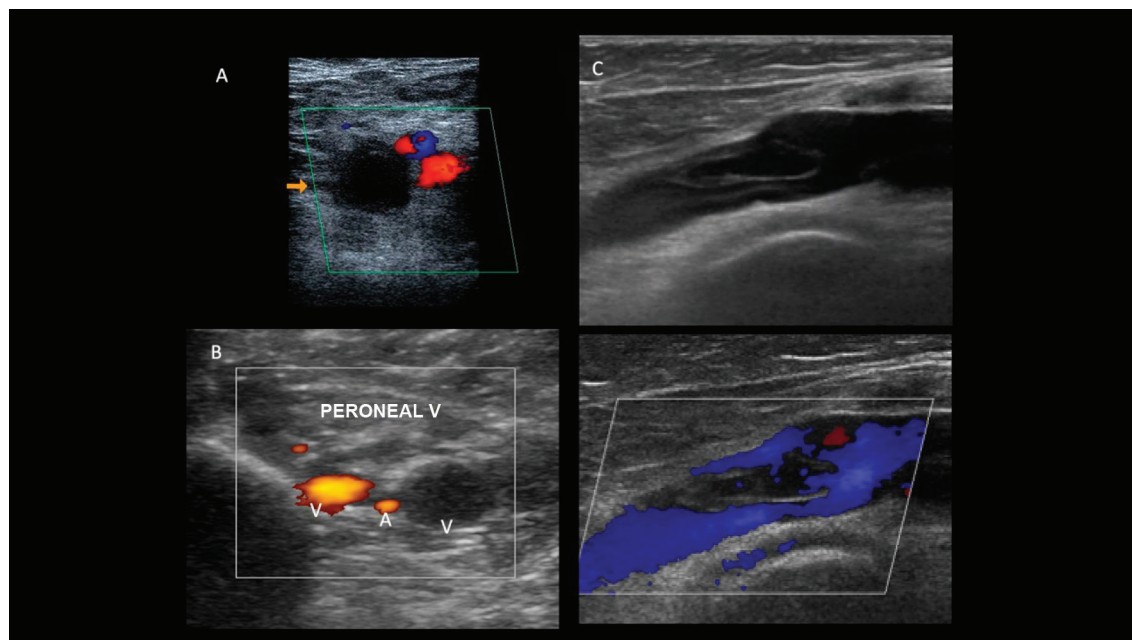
Trombose oclusiva e não oclusiva de aspecto agudo ao ultrassom. A: corte transversal da veia femoral comum; B: veias fibulares evidenciando dilatação e incompressibilidade sem evidências de fluxo ao mapeamento de fluxo em cores e ao Power Doppler; C: corte longitudinal da veia femoral comum com e sem mapeamento de fluxo em cores evidenciando trombo flutuante de aspecto recente e não oclusivo.
